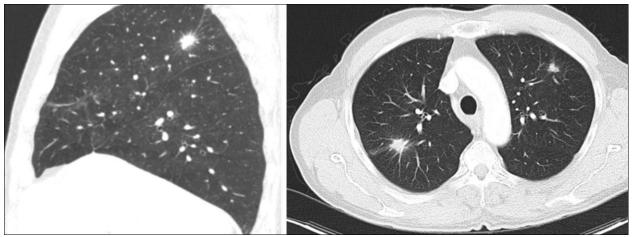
In the axial and sagittal CT planes, irregularly circumscribed nodular lesions are observed in both lungs that have evidence of corona radiata. Other lung parenchyma areas appear to be normal.
